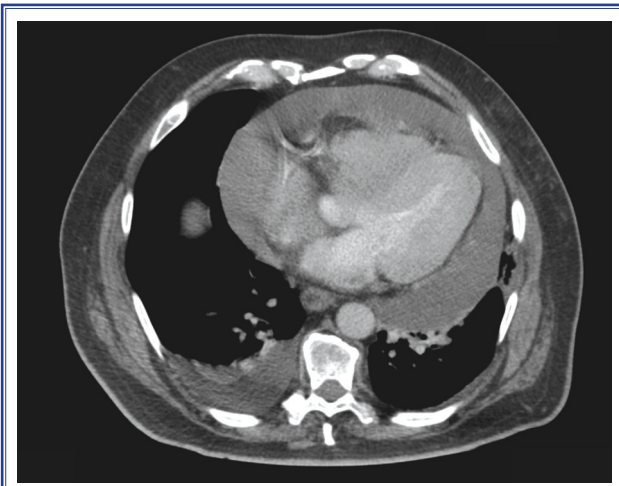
CT scan on admission.
